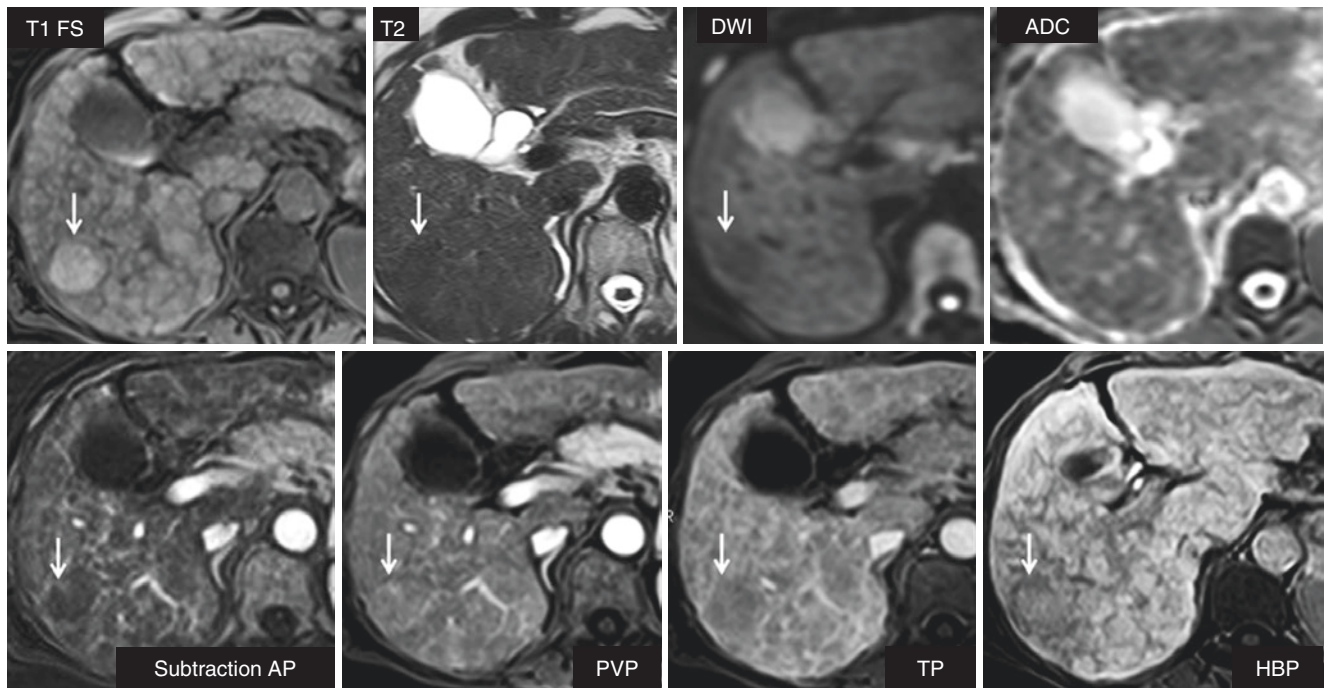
Multiparametric MRI evaluation of the liver in a cirrhotic patient—T1 Fat Sat, T2 wi, DWI and ADC, dynamic 3D T1 FatSat acquisition with Gd-EOB-DTPA in arterial phase (subtraction), portal
